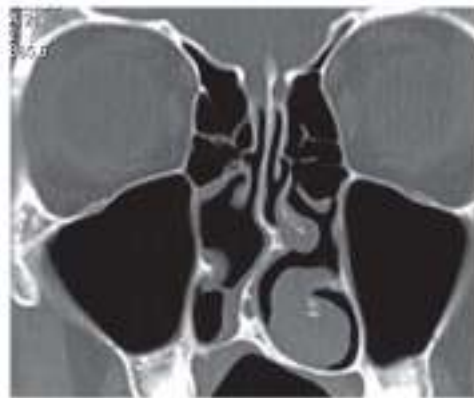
CT PNS in Coronal plane showing Nasal Septal Spur.³⁴
